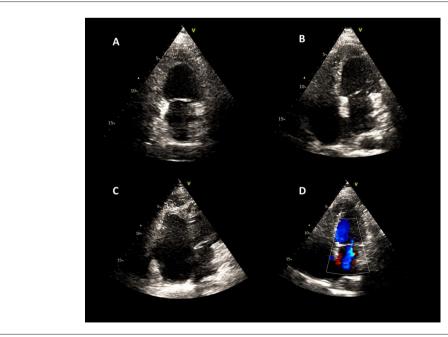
Transthoracic echocardiogram images of a patient diagnosed with HES and apical obliteration of the left ventricle in the apical 2-chamber view (A), apical 4-chamber view (B) and from the right ventricle to the apical 4-chamber view directed towards the RV (C). A mild degree of mitral regurgitation is observed on color Doppler echocardiography.
